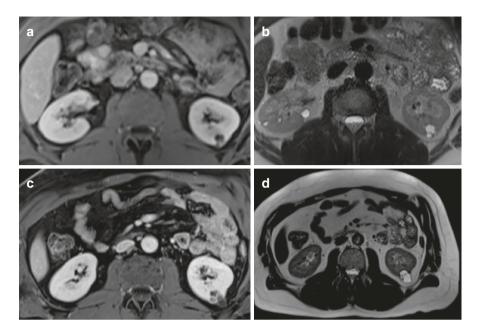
Axial GE T1-weighted fat-suppressed (a) and axial TSE T2-w (b) images showing a wellcircumscribed cystic lesion with thin septa located in the left kidney, consistent with Bosniak IIF lesion. The same acquisitions (c, d), obtained 1 year later, showed an increase of lesion size and number of septa, now configuring a Bosniak type III cyst
